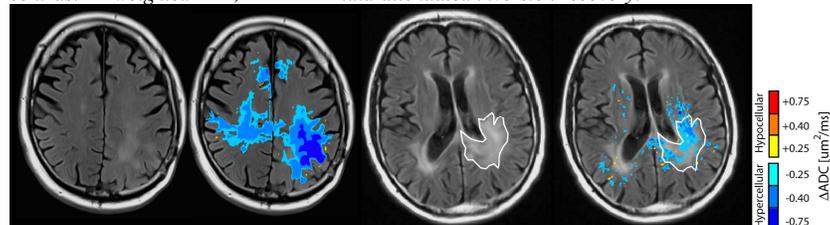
Graded fDMs applied to the whole brain aids in visualization of tumor invasion beyond FLAIR signal abnormality, as demonstrated in two patients. Left: FLAIR images in a patient with recurrent GBM. Second from Left: Graded fDM shows invading tumor. Second from Right: FLAIR image in an anaplastic astrocytoma patient. Right: Graded fDMs.
